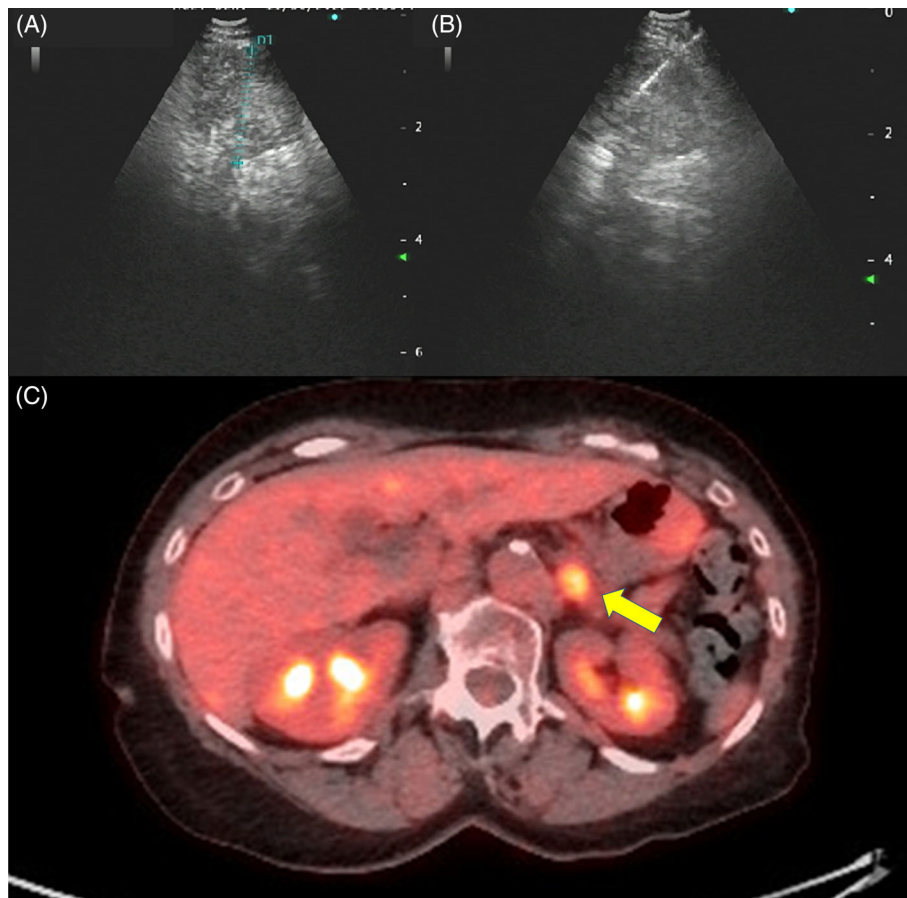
(A) Endobronchial ultrasound sound image of left adrenal gland 20 mm nodule. (B) Endobronchial ultrasound guided needle aspiration of left adrenal gland 20 mm nodule. (C) Positron emission tomography scan showing a maximum SUV uptake of 5.2 in left adrenal gland (yellow arrow).
